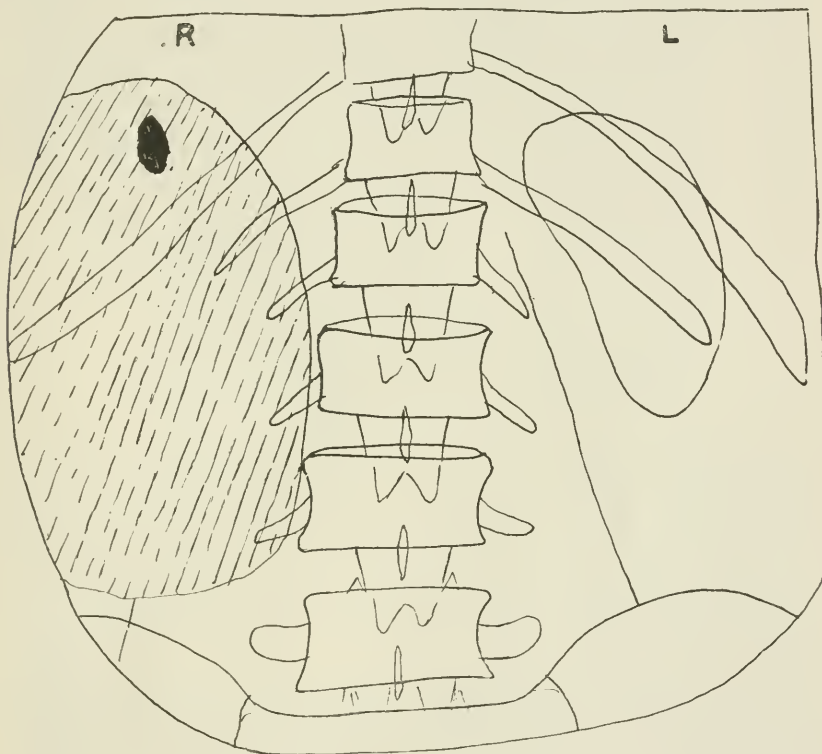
TRACING OF THE FIRST ROENTGENOGRAM SHOWING LEFT KIDNEY OUTLINE OF THE LARGE CYST AND PRESENCE OF A CALCULUS
